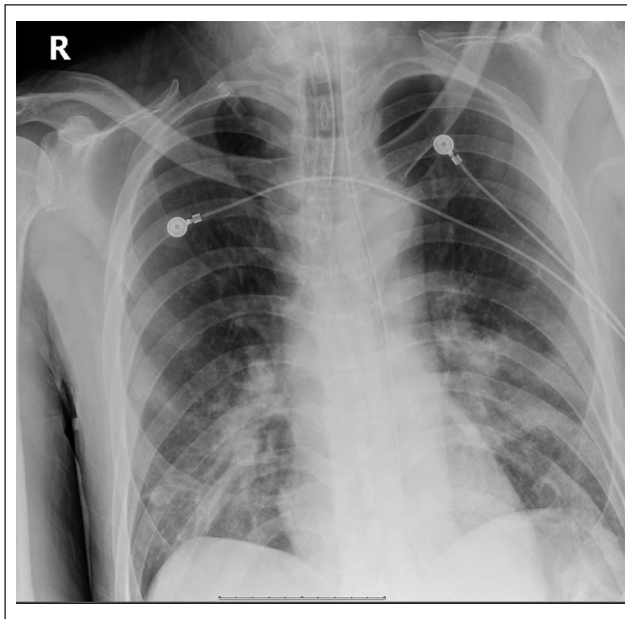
AP chest X-ray, 56-year-old male, diffuse bilateral multi-lobar opacities.
